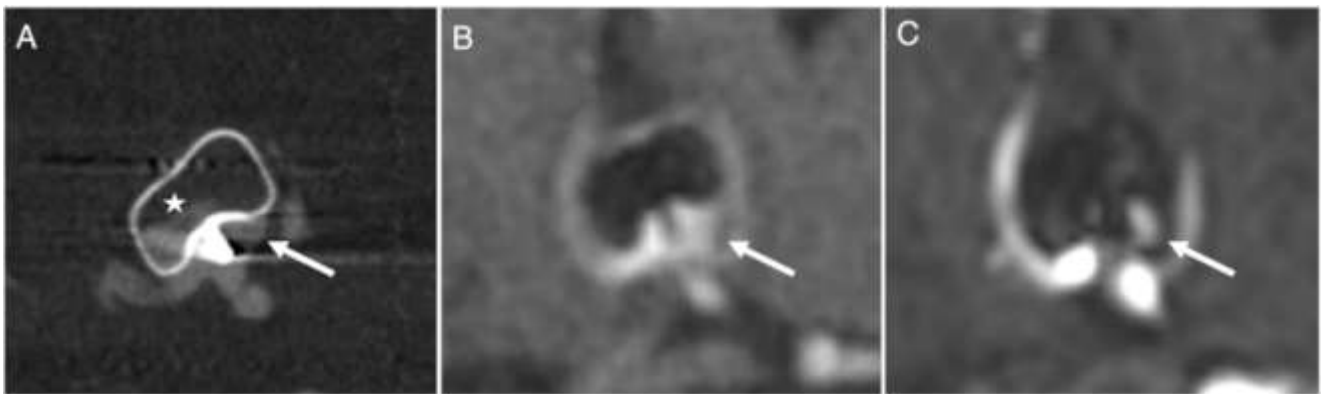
Follow-up of an incidental ACoA-Aneurysm treated with a WEB-device. Note the deformation of the WEB excellently depicted in FDCT (A, arrow) and UTE MRI (B, arrow). The shape of the WEB cannot be clearly visualized using TOF MRA after contrast administration (C). The perfusion within the WEB-device however cannot be visualized with neither MRI technique (asterisk in A) due to radio-frequency shielding effects.
